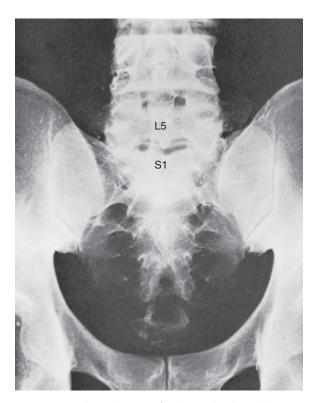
Anterior radiographic view of lumbosacral and sacroiliac articulations. Load transfer from the lumbar spine to the iliac bones via the costal processes of the first and second sacral segments is obvious.
